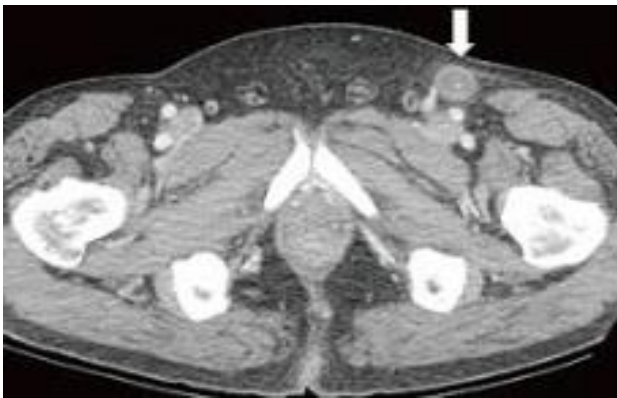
Imaging by CT scan of groin nodes.
